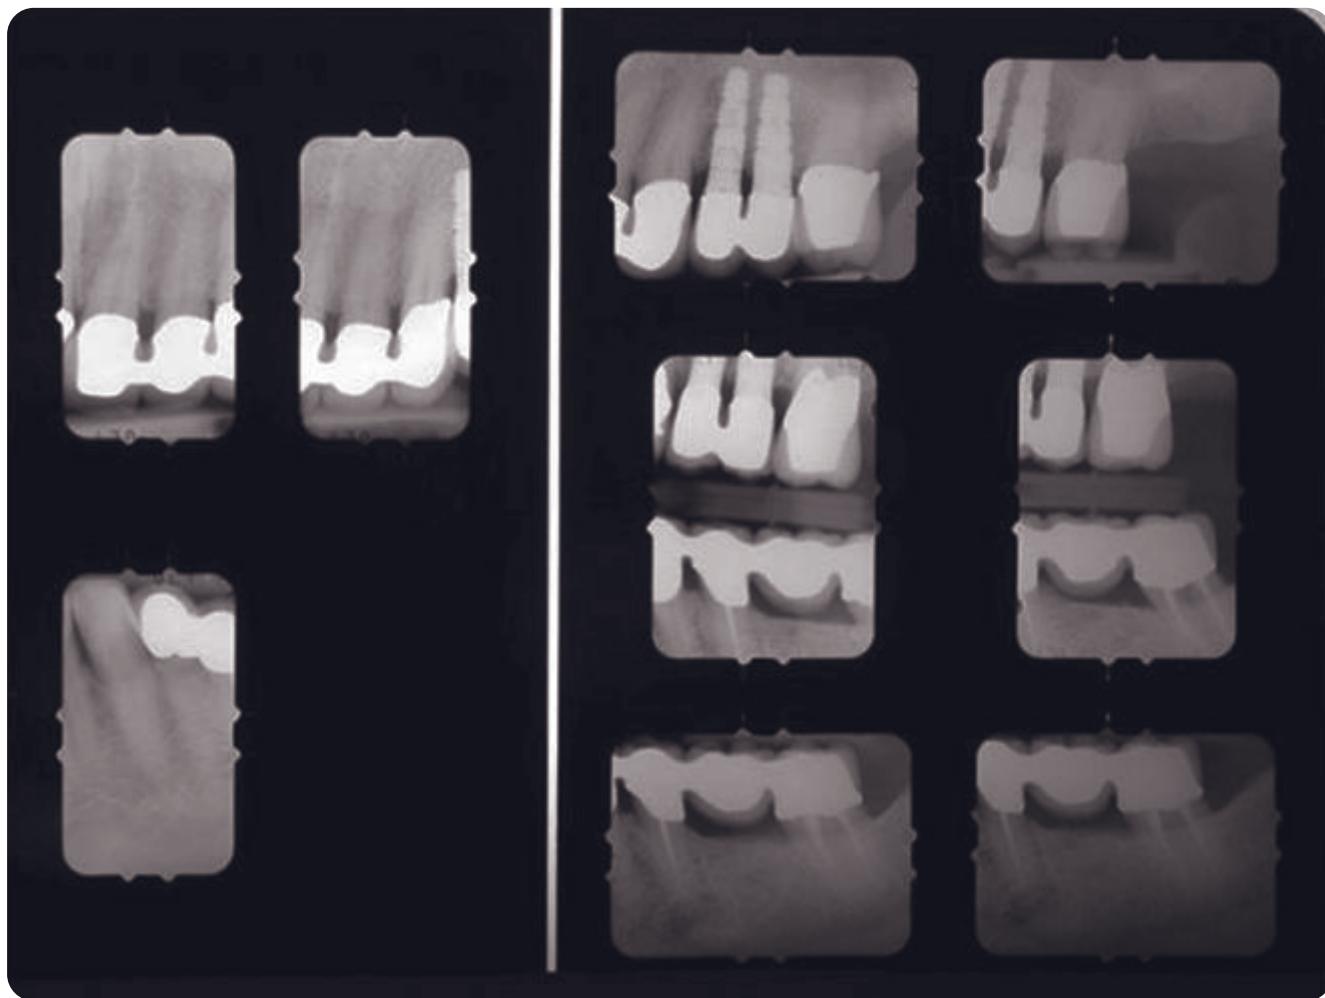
Posttreatment radiographs, left posterior.
